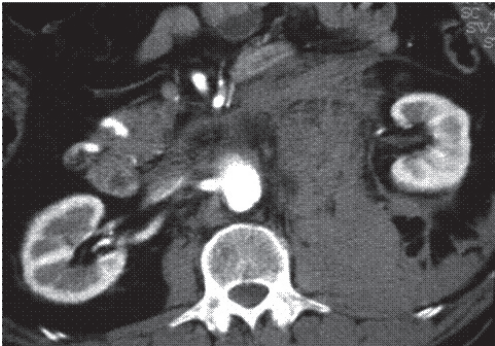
CT scan of rAAA indicating position of right renal artery.
